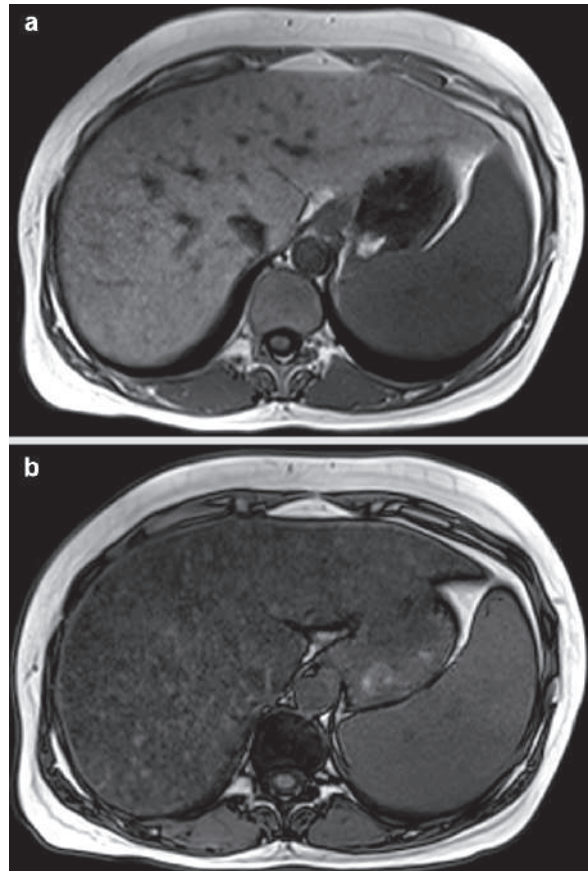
Axial T1W in-phase (a) and T1W out-of-phase (b) MRI in a patient with liver steatosis shows drop in the liver signal intensity >44% in the T1W out-of-phase image (b), diagnostic of hepatic steatosis
